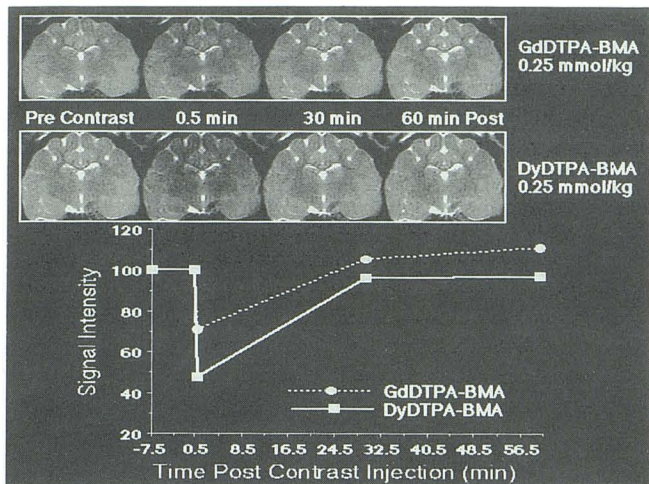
Injection of 0.25 mmol/kg DyDTPA-BMA produced a maximum 57% reduction in signal intensity. The resulting T2-weighted image (acquired at 0.5 min) had excellent gray matter-white matter differentiation. In the corresponding GdDTPA-BMA-enhanced image there was a maximum 24% reduction in signal intensity. Note that the GdDTPA-BMA-enhanced images acquired at 32.5 and 56.5 min after contrast injection were hyperintense relative to the baseline precontrast image.
